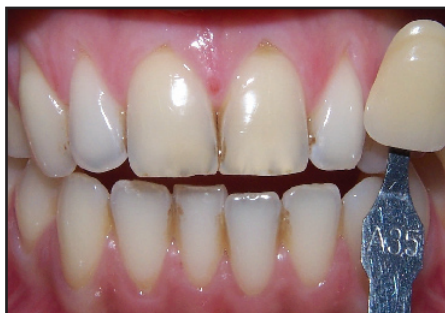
Case Number 1: This patient had two central incisors that were traumatised due to minor trauma from a swimming pool incident. See the radiograph which shows obliteration of the upper right central incisor and dentine bridge formation on the upper left incisor. The treatment involved using 10% carbamide peroxide for a period of two weeks on all the upper teeth and then 20% carbamide peroxide on the two central incisors for a period of three weeks. The patient experienced very little sensitivity during the bleaching treatment
